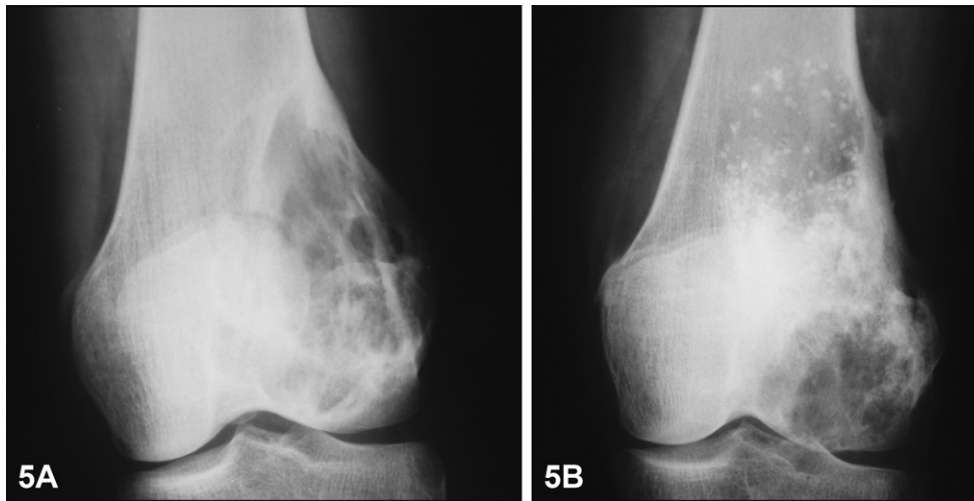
Case 9: AP radiographs. (A) Benign fibrous histiocytoma: well limited lytic lesion. September 1988. (B) March 1996. Lytic aggressive lesion centered on the epiphysis: Fibrosarcoma.
